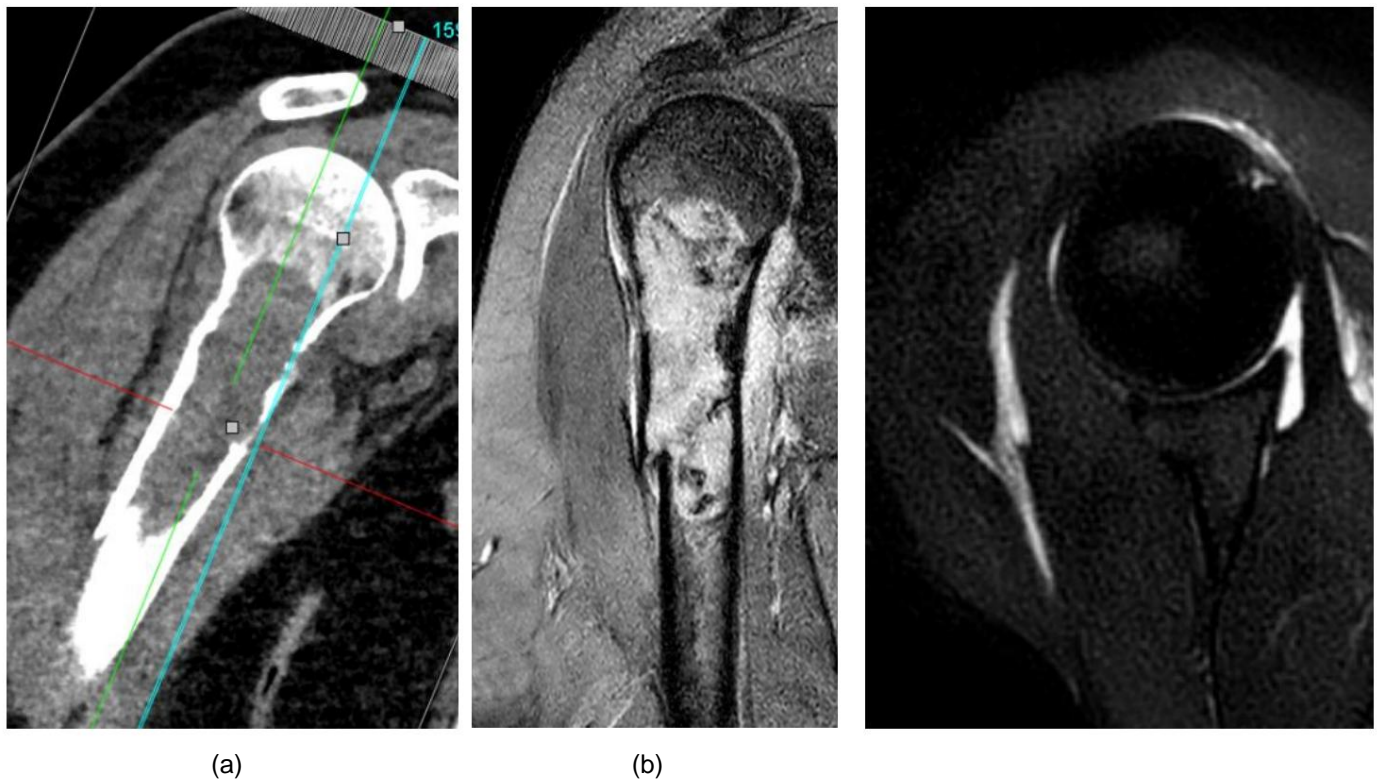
Radiological findings at diagnosis. (a) The CT shows a permeative pattern of the metaphysodiaphyseal cortex of the upper third of the humerus with an intramedullary mass that causes pathological fracture; (b) The MRI shows a well-defined, homogeneous mass, with little soft tissue component, without osteoid or chondral matrix and without the presence of "skip lesions", and which quickly and sustainably captures contrast; (c) Axial view of the MRI shows the presence of bruise.
